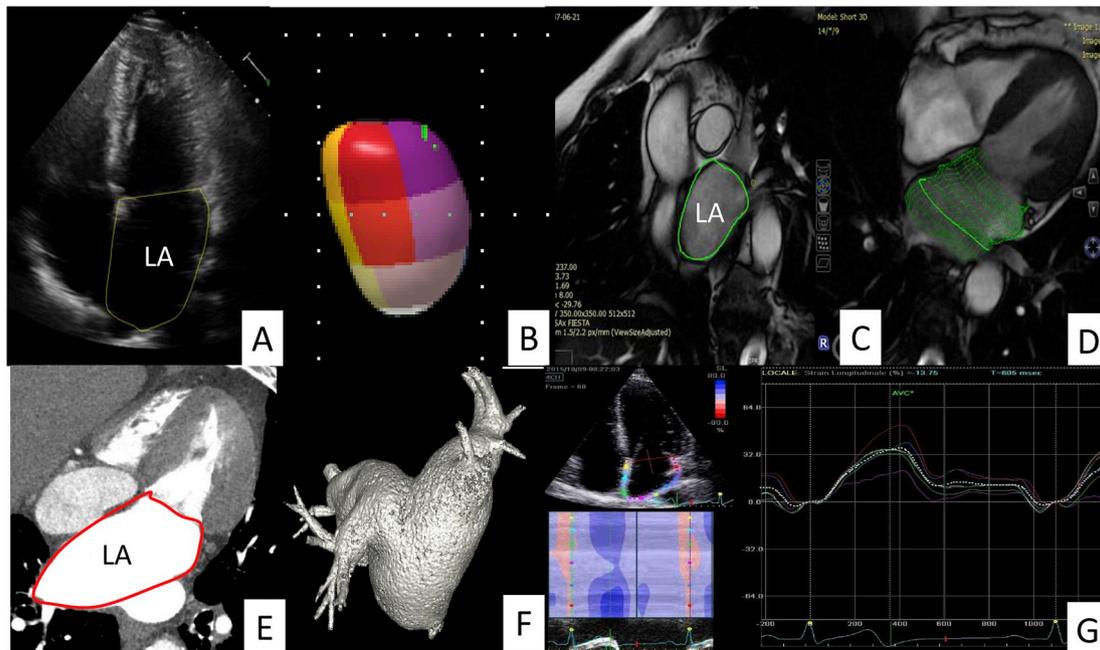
A. TTE 4 Chamber Long Axis view showing LA area measurement (yellow line). B. 3D echocardiography measurement of LA volume. C. CMR SSFP cine Short Axis Stack for LA volume measurement and left atrial CMR 3D volume rendering (D). E. CCT measurement of LA area (red line) F. CCT 3D volume rendering of LA. G. Strain with speckle tracking method of a LA. CCT: cardiac computed tomography; CMR: cardiac magnetic resonance; TTE: transthoracic echocardiography; LA: left atrium; SSFP: steady state free precession sequence.
